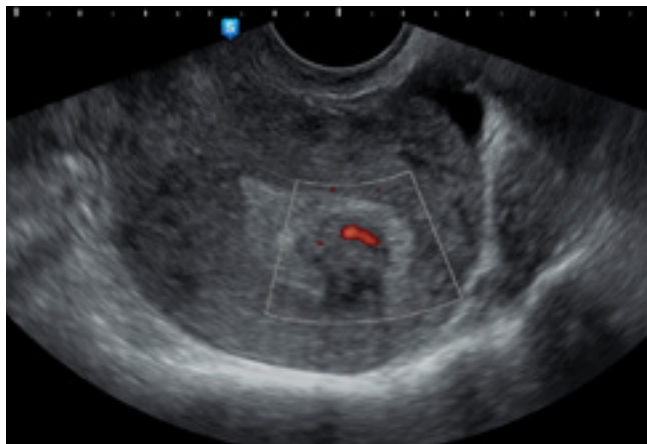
Uterine myoma. Discrete flow on color Doppler (stage 1)
